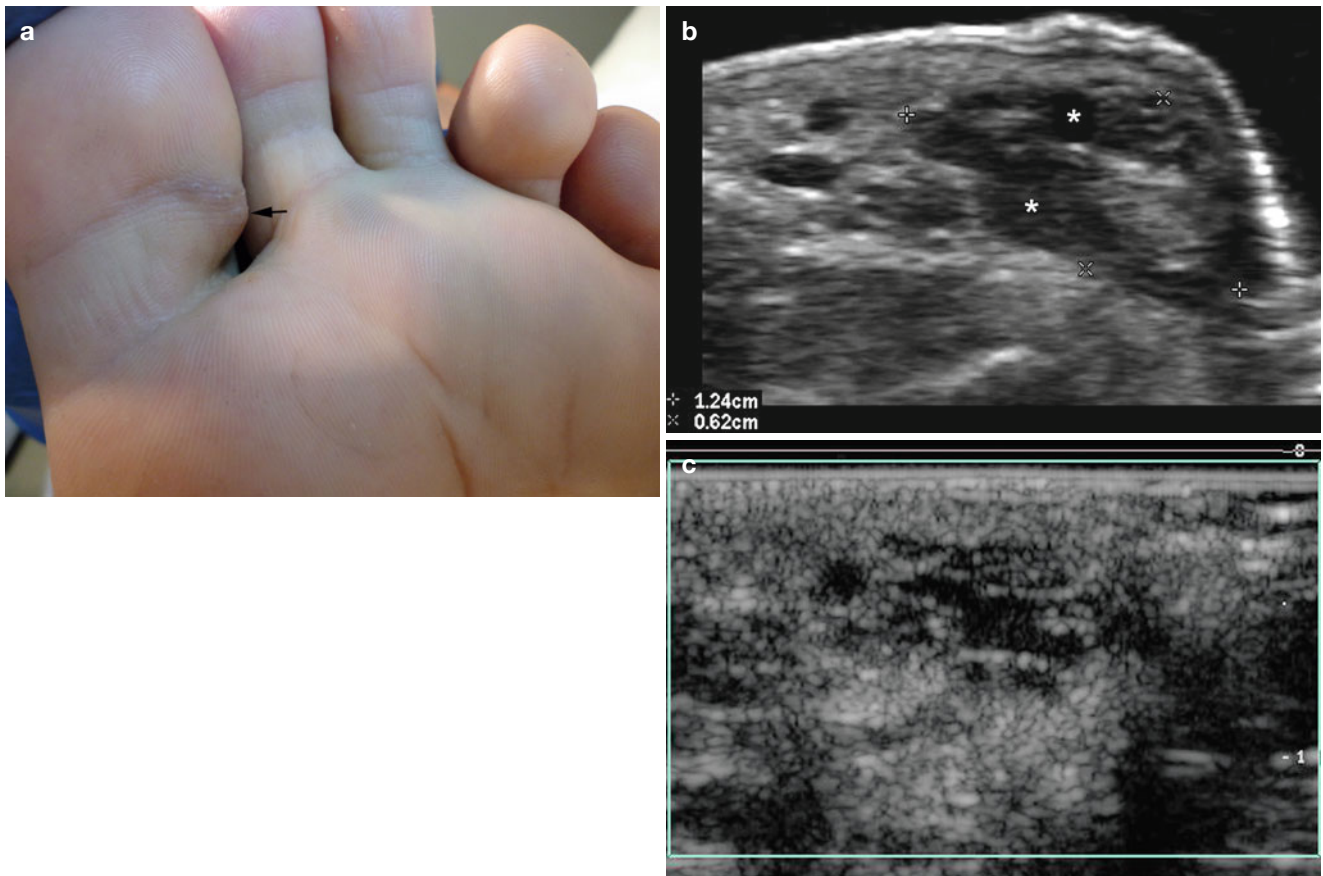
(a-c) Low-flow lymphatic vascular malformation. (a) Clinical image demonstrates slightly erythematous swelling (*arrow*) in the lateral aspect of the left toe. (b) Grey scale ultrasound image (transverse view) shows 1.24 × 0.62 cm area with multiple anechoic tubules
